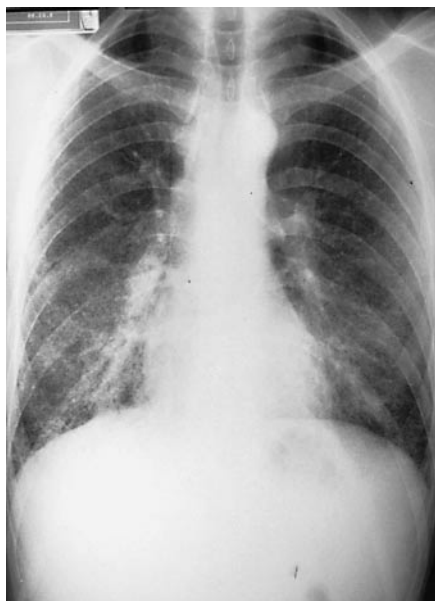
Chest posterior-anterior roentgenogram showed bilateral reticulonodular infiltrates with a diffuse pattern.
